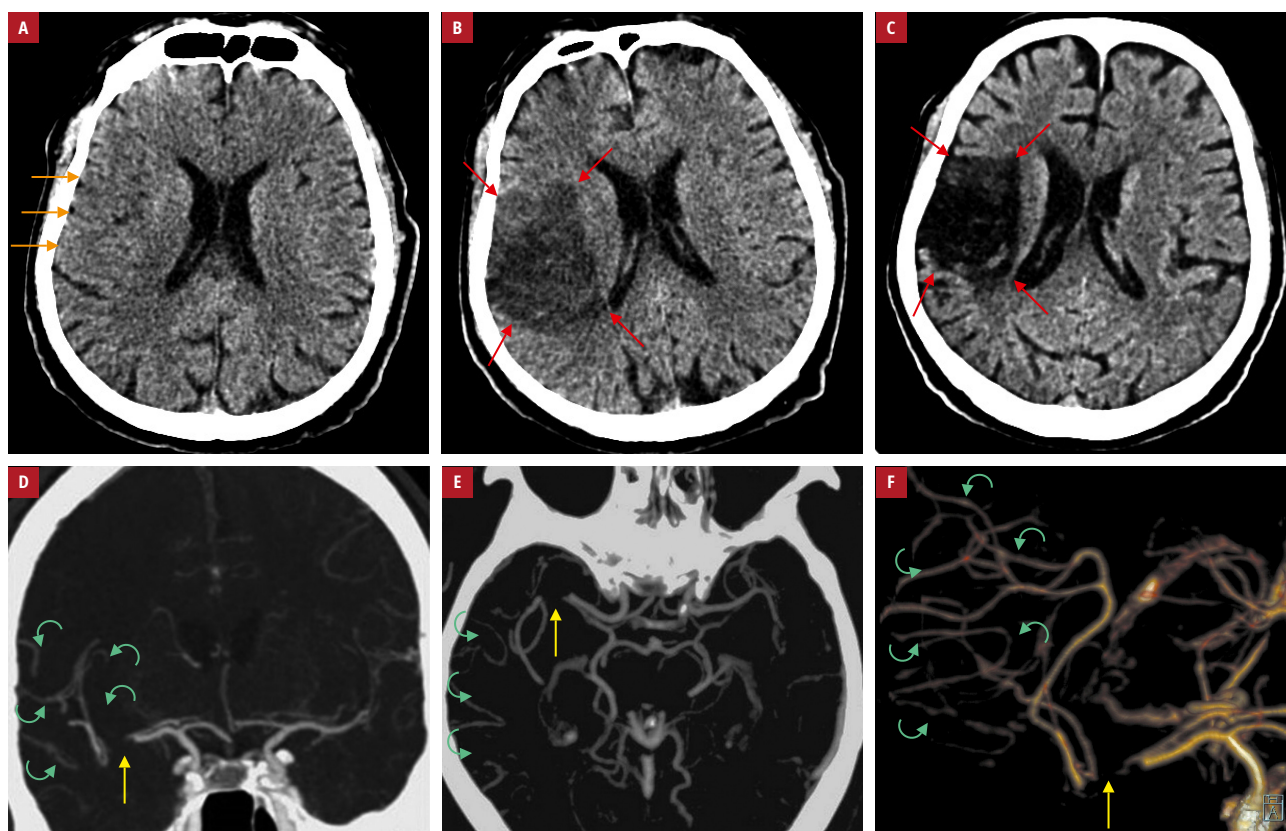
Cerebral infarct in a patient with untreated emergent large-vessel occlusion (ELVO) acute ischemic stroke. Panels A, B, and C show infarct evolution in the absence of level 1A (class 1A) international guideline-mandated¹ management by mechanical thrombectomy: A – axial plain computed tomography (CT) at baseline (up to 4 hours after ELVO onset); only mild early signs of infarction with effacement of the sulci (orange arrows) and mild cortical hypodensity (ASPECTS score 8); B, C – axial, nonenhanced CT at 2 weeks (B) and 3 months (C), showing the demarked infarcted area (red arrows); D, E – CT angiography at the time of presentation (at the same time-point as in A), showing the occlusion of the right distal M1 segment of the middle cerebral artery (yellow arrow) and very good collateral supply (green arrows; Tan score 3) in coronal (D) and axial (E) planes. Collaterals play an important role in cerebral tissue salvage, influencing favorably the penumbra to core ratio. Evidence supports the role of collateral assessment in identifying patients likely to benefit from mechanical thrombectomy;¹ F – a 3-dimensional reconstruction of the baseline CT angiography with the occlusion of the M1 segment of the right middle cerebral artery (yellow arrow, coronal view) and a rich collateral supply (green arrows). Note that thrombolytic therapy (which was not implemented in this patient due to a recent major surgery) is much less effective than MT with or without intravenous thrombolysis.¹ With MT, for every 100 patients treated, 22 additional patients reach independence (modified Rankin score, 0–2) at 3 months and 33 more patients achieve early neurological recovery (Saposnik et al, see the additional reference list [Supplementary material]).
